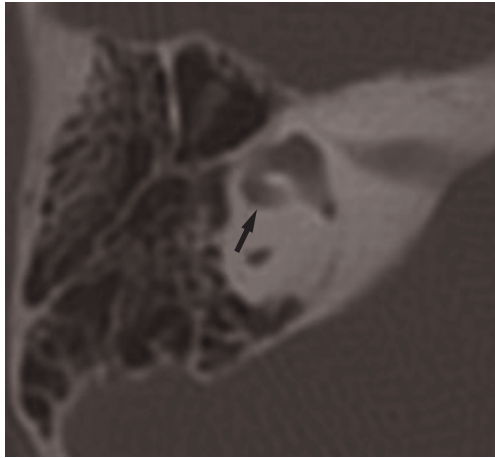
Axial CT scan. Short lateral semicircular canal (arrow).
